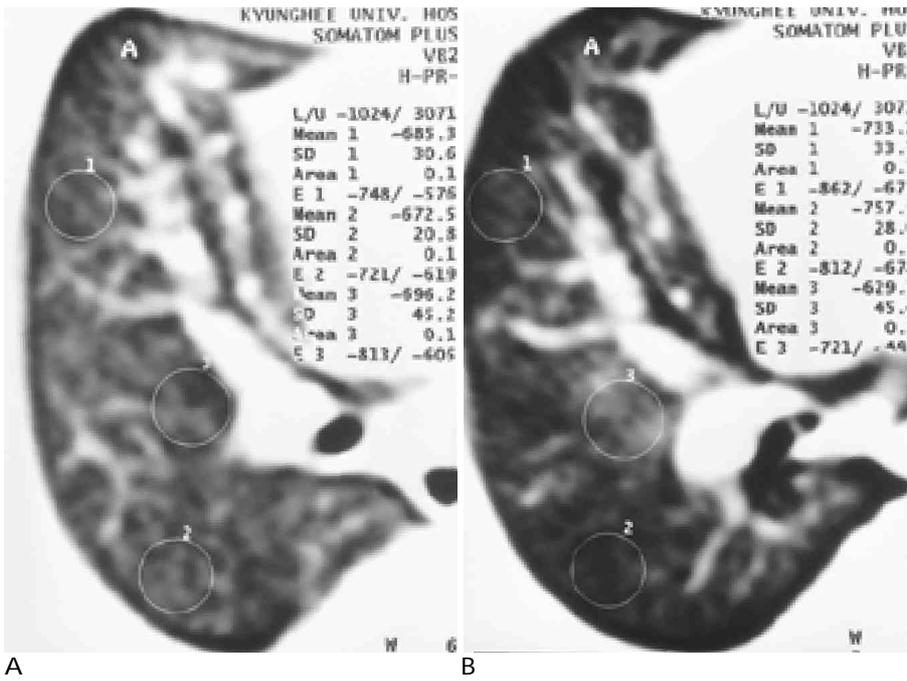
The difference of CT numbers between pre- and postembolization. The difference of attenuation between pre-(A) and postembolization CT(B) are significant in peripheral lucency and perivascular ground glass opacity.
